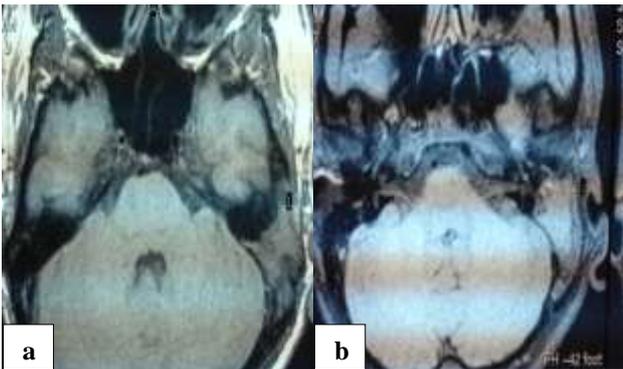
(a) MRI T1 weighted image left mastoid, and (b) MRI with gadolinium contrast left mastoid.
